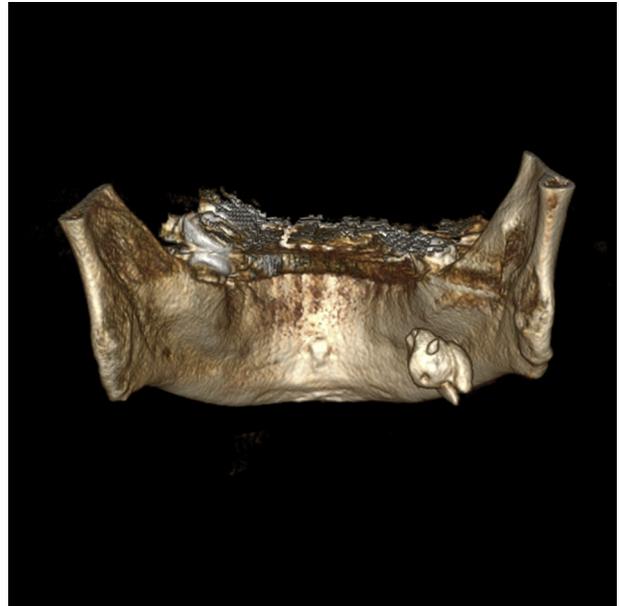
Patient 2. Cone-beam computed tomography image, 3-dimensional posterior view.
